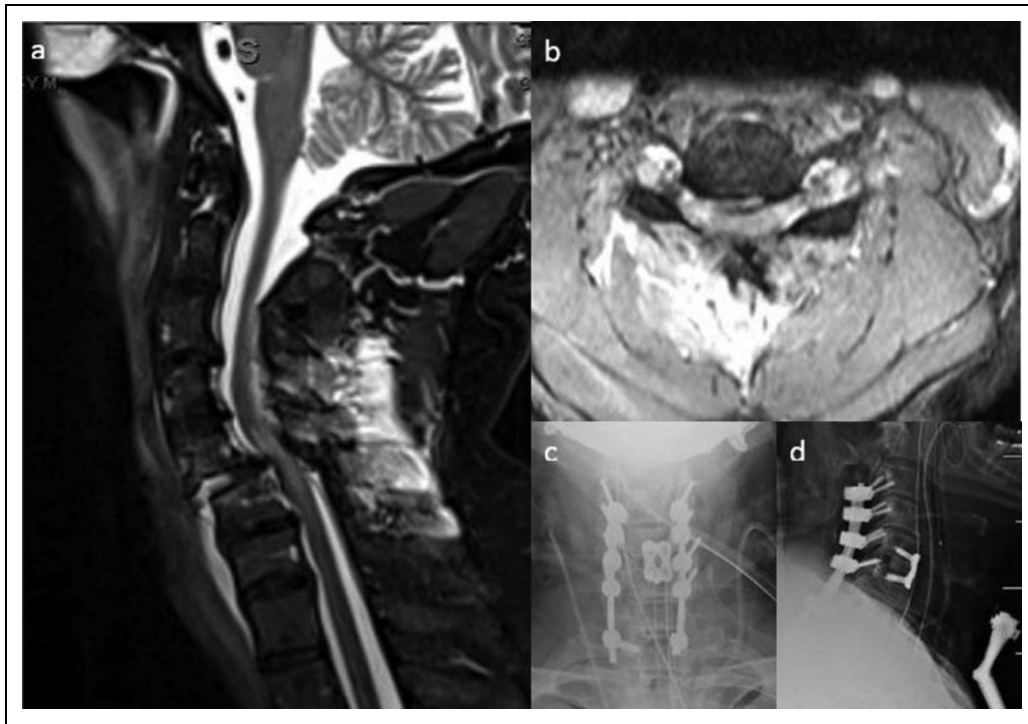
A 54-year-old male presenting with bilateral facet dislocation. Use of an M2 modifier designates the presence of a critical disc herniation. (a) Sagittal and (b) axial T2 MRI showing anterior translation of C5 with critical disc herniation and cord injury at C5-6. (c) AP and (d) Lateral plain films show cervical fixation with ACDF performed prior to posterior cervical fixation to address the critical disc herniation.
